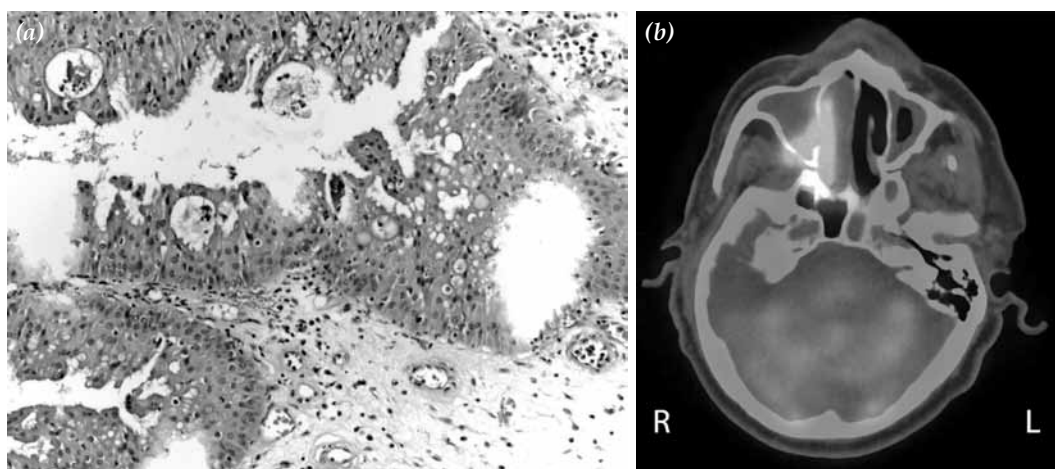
In inverted papilloma, (a) areas including oncocytic epithelium (H-E x 200). (b) Positron emission tomography/computed tomography image of the same patient.
